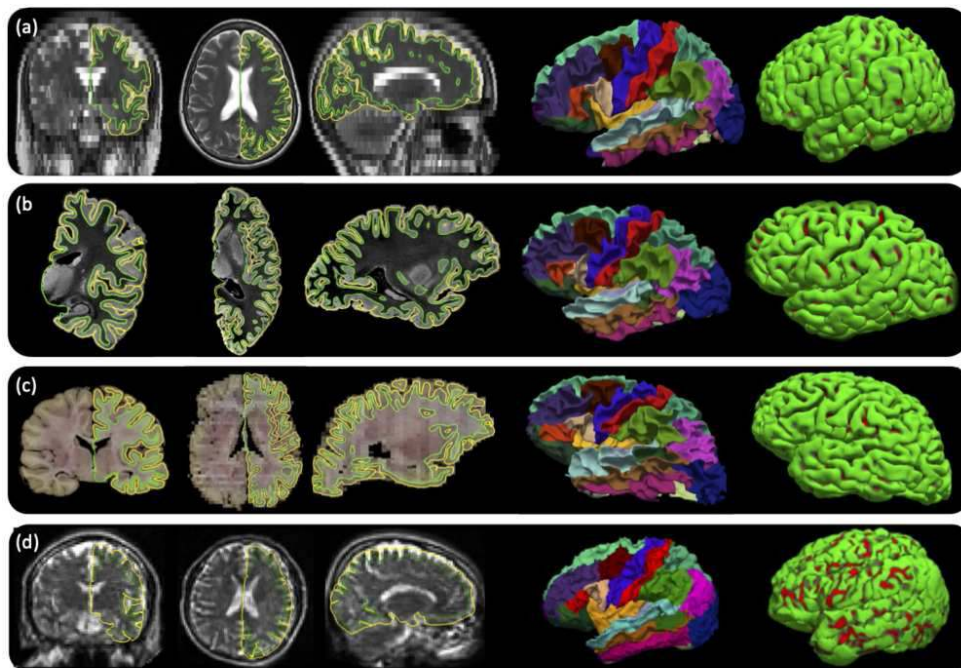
Sample outputs of cortical surfaces for different scans from the different datasets. The left WM and pial surfaces are overlaid on the orthogonal views. The 3D-rendered WM and pial surfaces are shown on the right. The cortical parcellation is overlaid on the WM surface. (a) Axial T2-weighted scan with 0.9x0.9x6mm resolution. (b) Ex vivo MRI scan at 0.5x0.5x0.5mm resolution. (c) A 3D reconstruction of the coronal dissection photograph at 0.5x0.5x4mm. (d) A portable low-field T2 axial scan at 2.5x2.5x2.5mm resolution.
